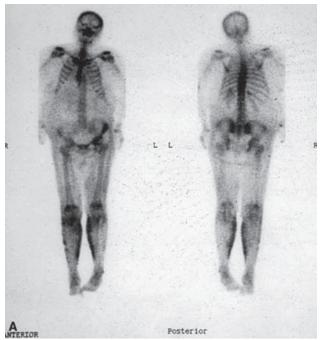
Bone scintigraphic abnormalities in calcific uremic arteriolopathy. Calf calcification in a patient with gross ulcerations in both legs from the popliteal fossae to the ankles. (With permission from reference 14.)
